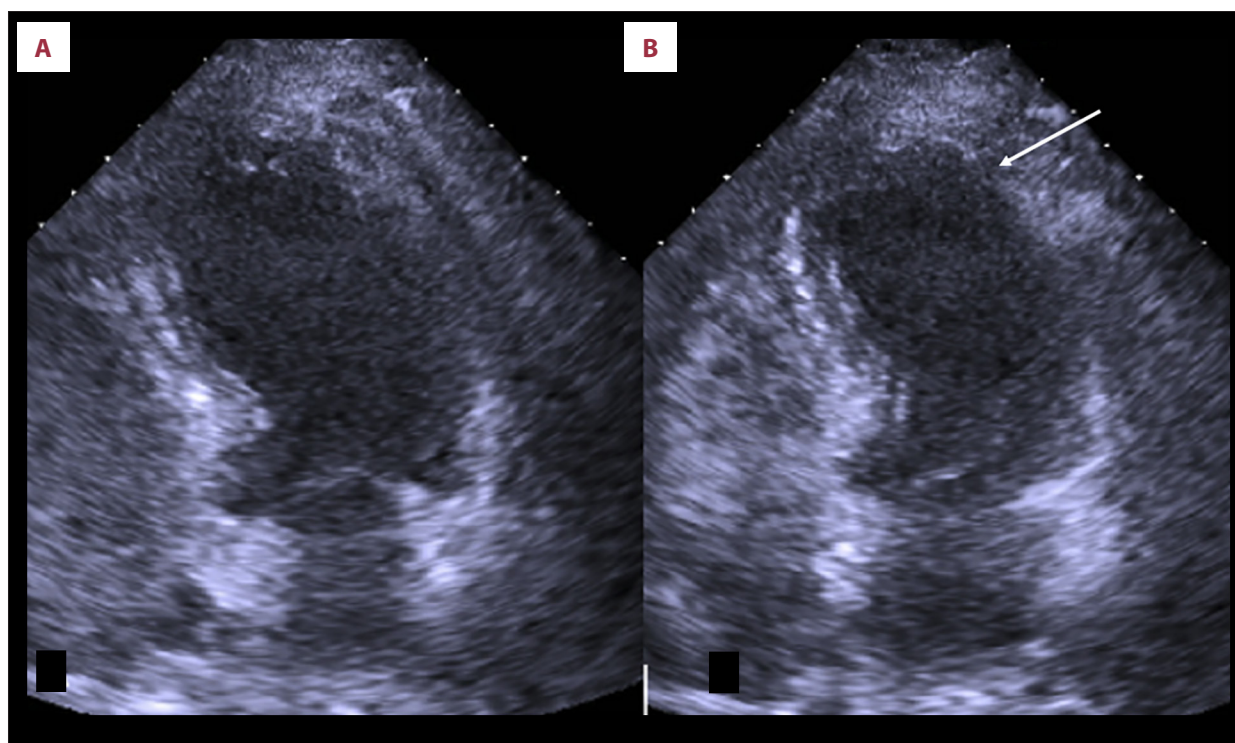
Takotsubo cardiomyopathy event in 2016: transthoracic echocardiogram with apical 4-chamber view; diastole (A), systole (B). The arrow in B indicates akinetic mid-distal anterolateral wall and apex during systole.
